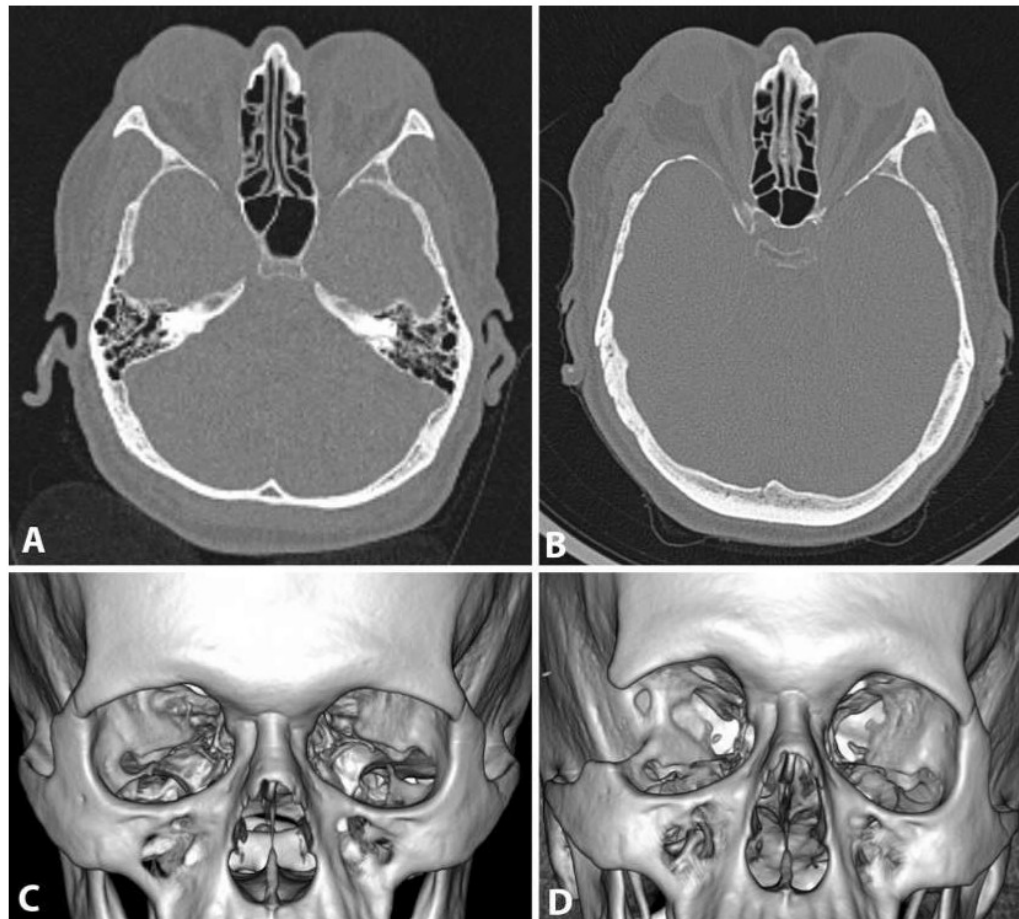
Computed tomography of pre- (a, c) and post- (b, d) right rim-off deep lateral decompression. Top: bone window axial slices. Bottom: 3-D reconstruction
